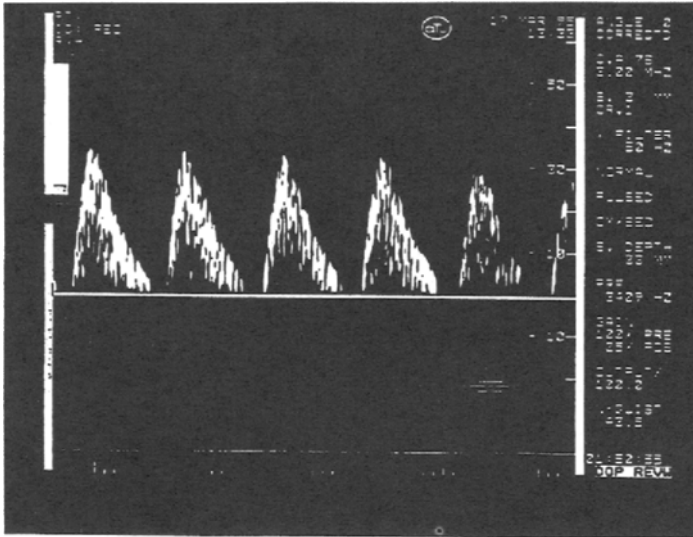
Doppler umbilical artery waveform pattern showing absent diastolic flow.
